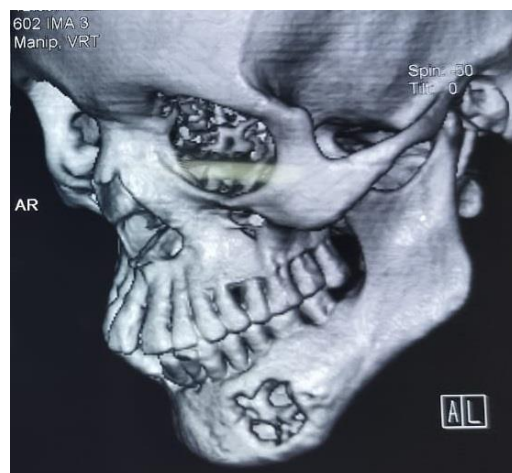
3- Dimensional CT Scan image showing buccal cortical perforation along with expansion of inferior border of mandible.
